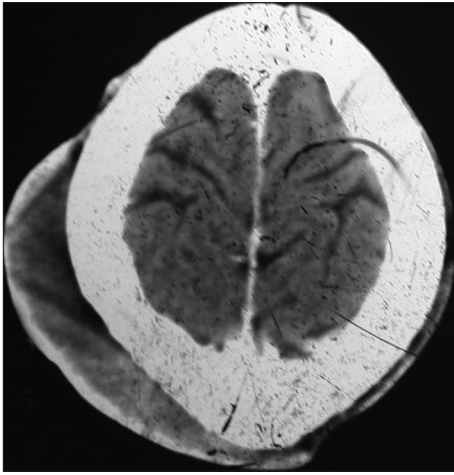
Computed tomography showing hypodense extra-calvarial mass with no enhancement
